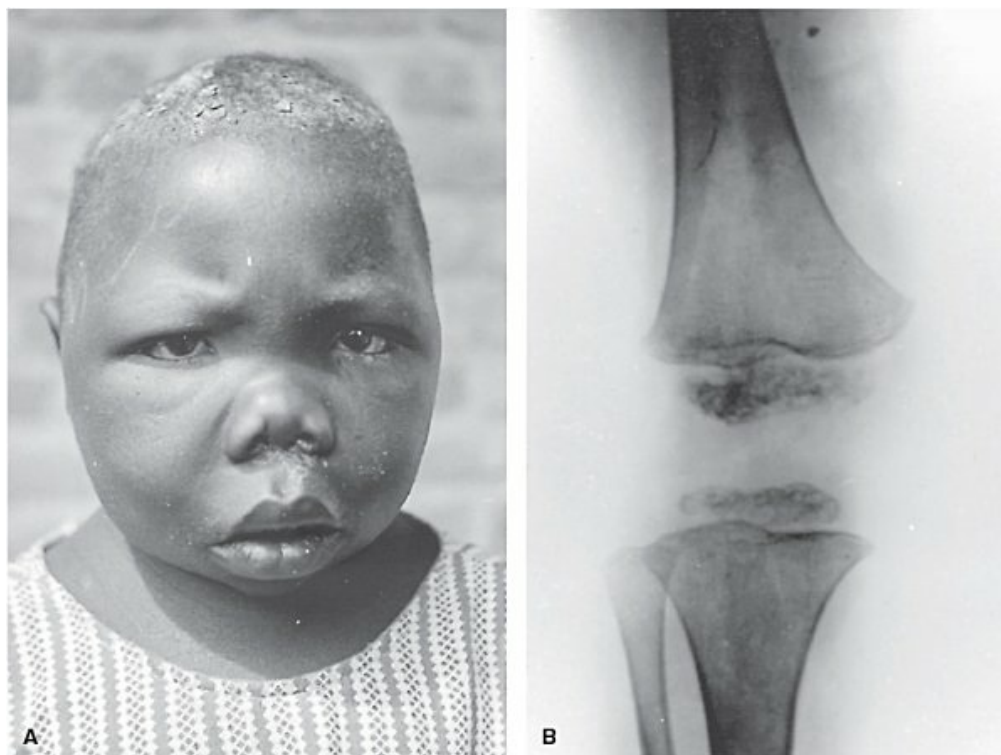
Clinical appearance (A) and knee x-ray (B) of a 17-year-old myxedematous cretin with a height of 88 cm (56% of normal for the local population) and a serum protein-bound iodine of 1.0 $\mu\text{g}/\text{dL}$. Bone maturation is estimated at 2 to 5 years. The x-ray film shows failure of modeling, and tibial and femoral epiphyseal dysgenesis. (Photograph courtesy of Professor F. Delange, Brussels, Belgium.)
